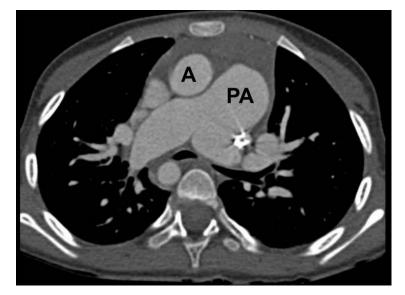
CT axial image of 6 year old girl with double outlet right ventricle has aortic root(A) and main pulmonary trunk (PA) arising in a parallel plane with aorta at right side and main pulmonary trunk at left side, which is designated as {_, _, D-MGA}.
